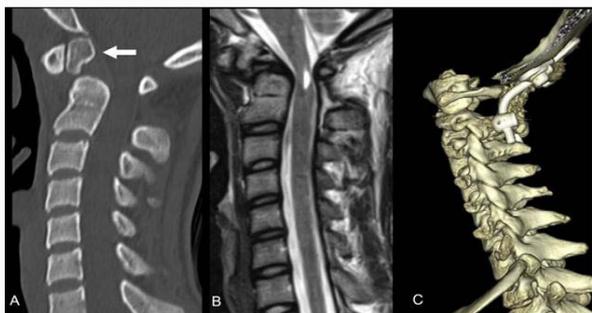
A) Sagittal CT imaging of cervical spine reveals an independent ossicle separated from the odontoid peg (os odontoideum; white arrow). B) T2-weighted sagittal MRI indicating a lesion with high signal intensity at C1 level in the spinal cord. C) Postoperative 3D CT imaging showing posterior occipital cervical reconstruction with screw-rod fixation in occiput-C2 lesion.
